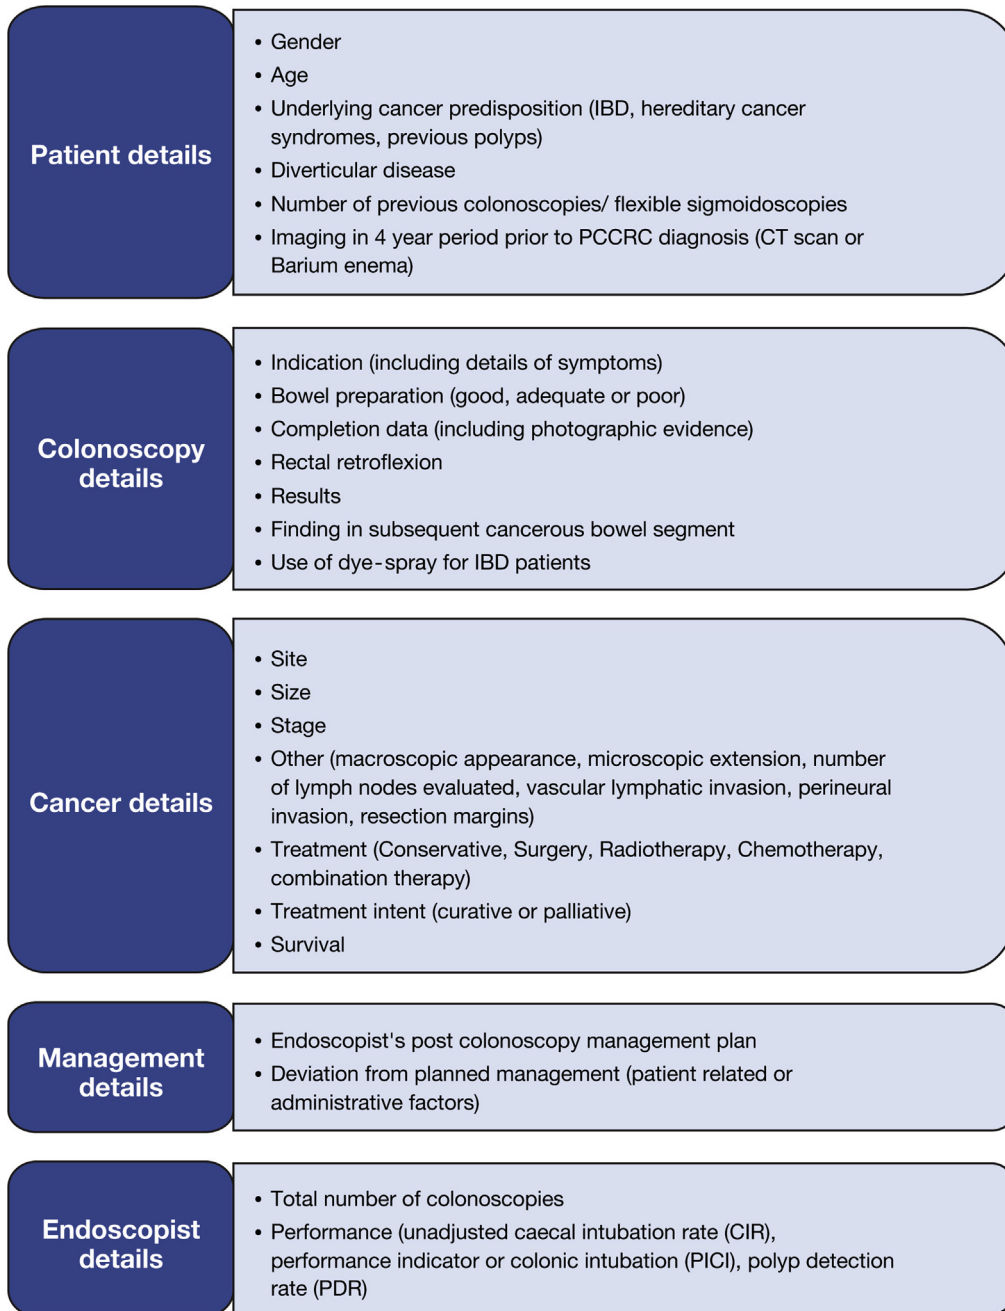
Data collected for each PCCRC. CT, computed tomography.
